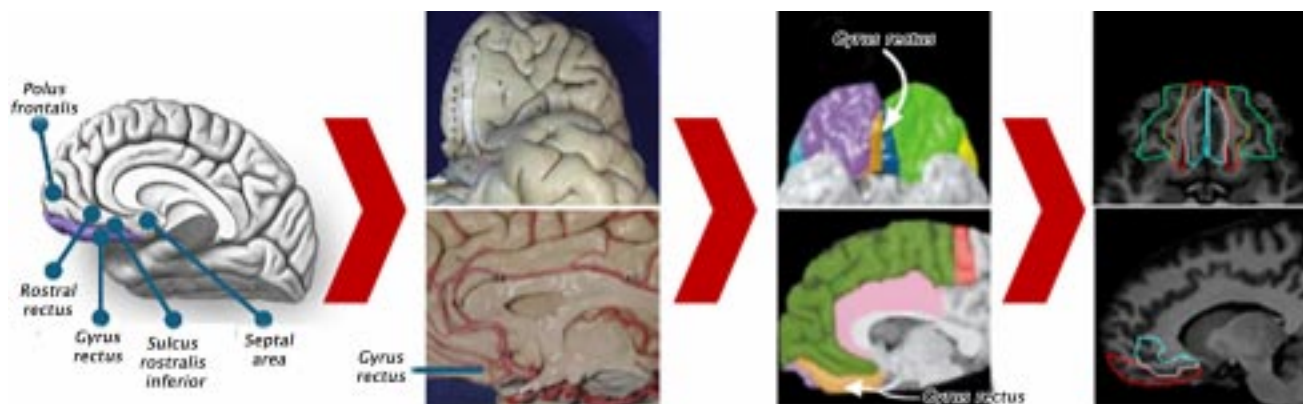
Anatomical landmarks and MRI morphometry.
